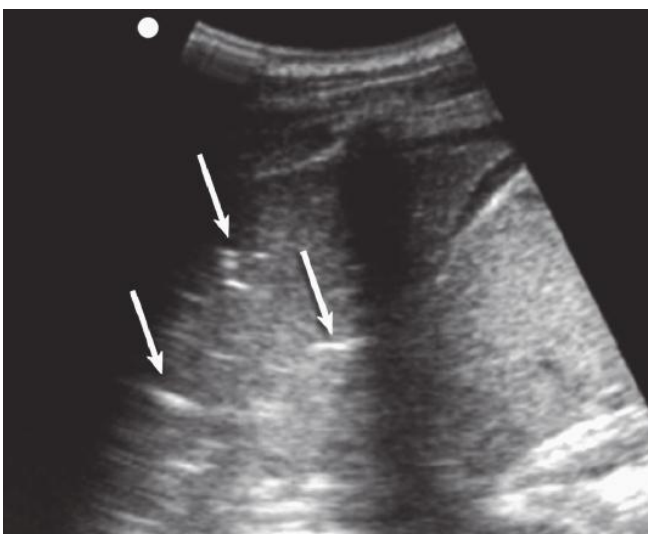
Arrows point to areas of pulmonary consolidation. [Reproduced with permission from Silva FR, Mills L: Chapter 7. Pulmonary, in Ma OJ, Mateer JR, Reardon RF, et al (eds): *Ma and Mateer's Emergency Ultrasound*, 3rd ed. New York: McGraw-Hill Education; 2014. Fig. 7-4, Part C, p. 177.]
